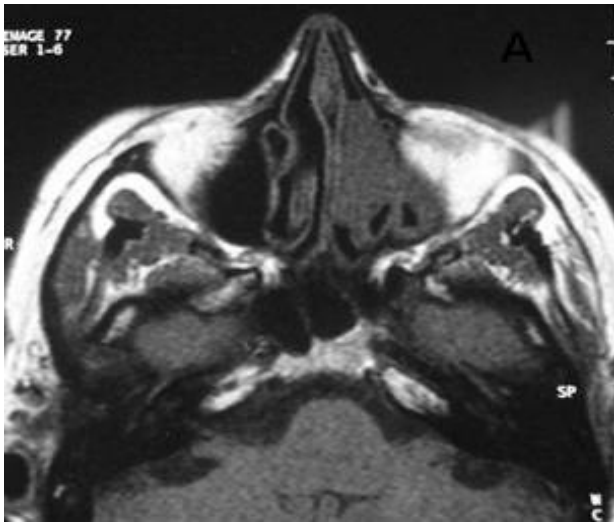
MRI of facial bone, T1 with Gadolinium
